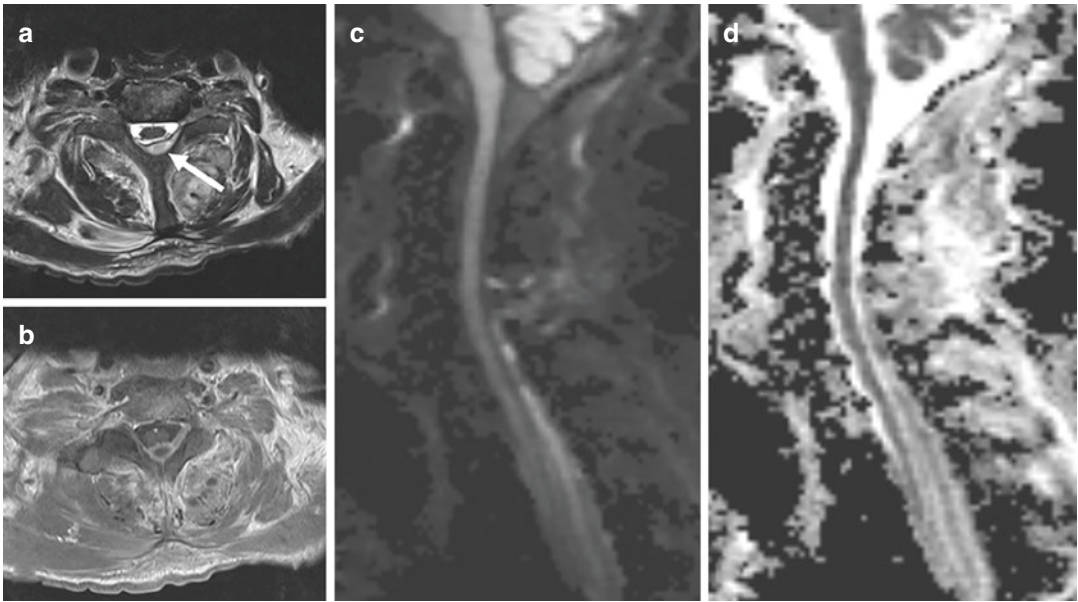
Epidural abscess in the cervical spine. Axial T2-weighted MRI (a) shows a heterogeneously hypointense epidural collection in the posterior spinal canal (arrow), which demonstrates peripheral enhancement on
